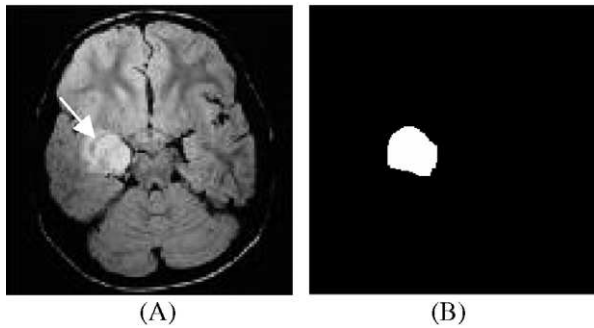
(A) T2 MR image. (B) Image with manually segmented tumor.
